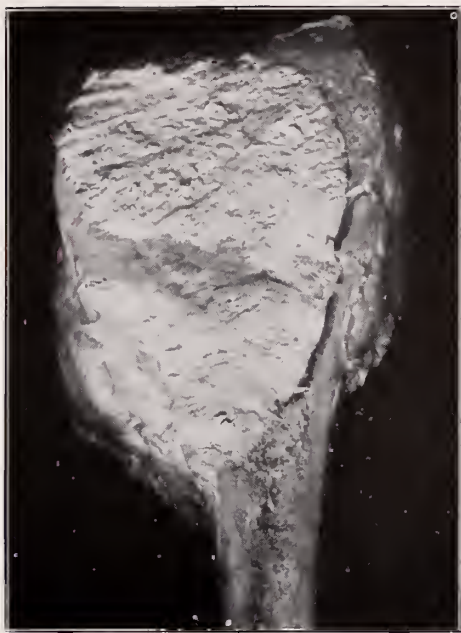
Path. No. 23407 (VIII). Central Fibro-sarcoma. Lower end of Femur. For x-ray see Fig. 18.
